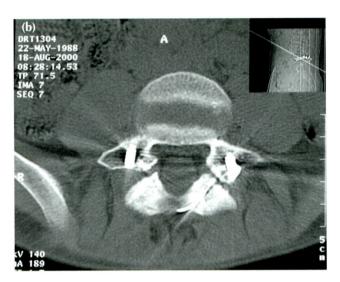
Figure The pars interarticularis of the same patient showing (a) bony union on radiography and (b) nonunion on computed tomography.
